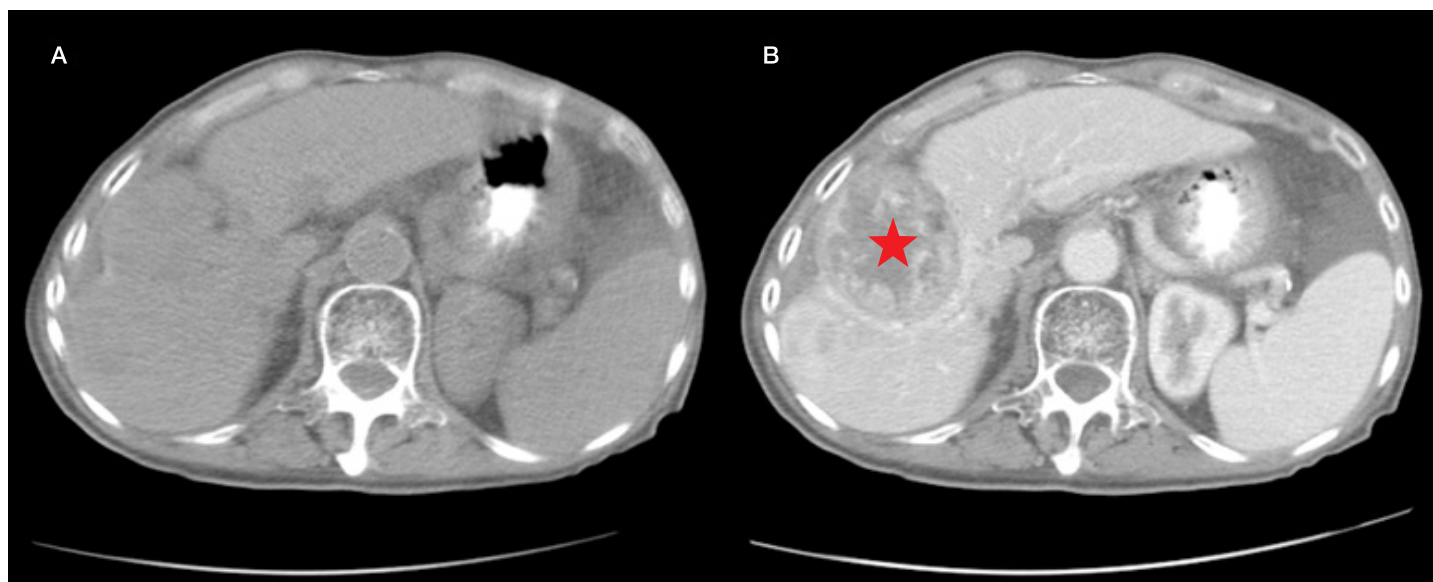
The impact of contrast in delineating a tumour. A, scout film. B, arterial phase axial CT image with tumour highlighted via a red star.
